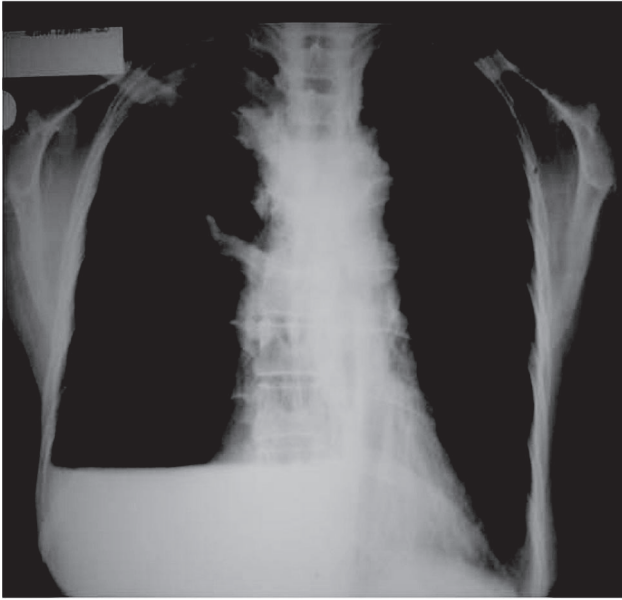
Chest radiograph shows a right hydropneumothorax.
